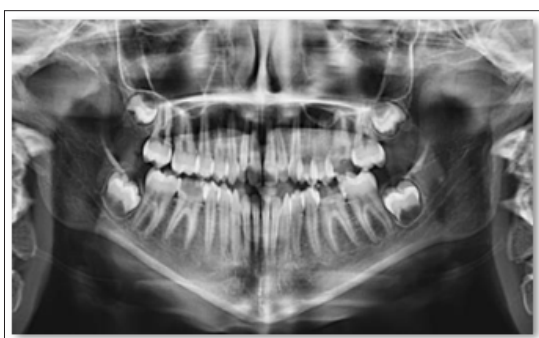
Panoramique X-ray
